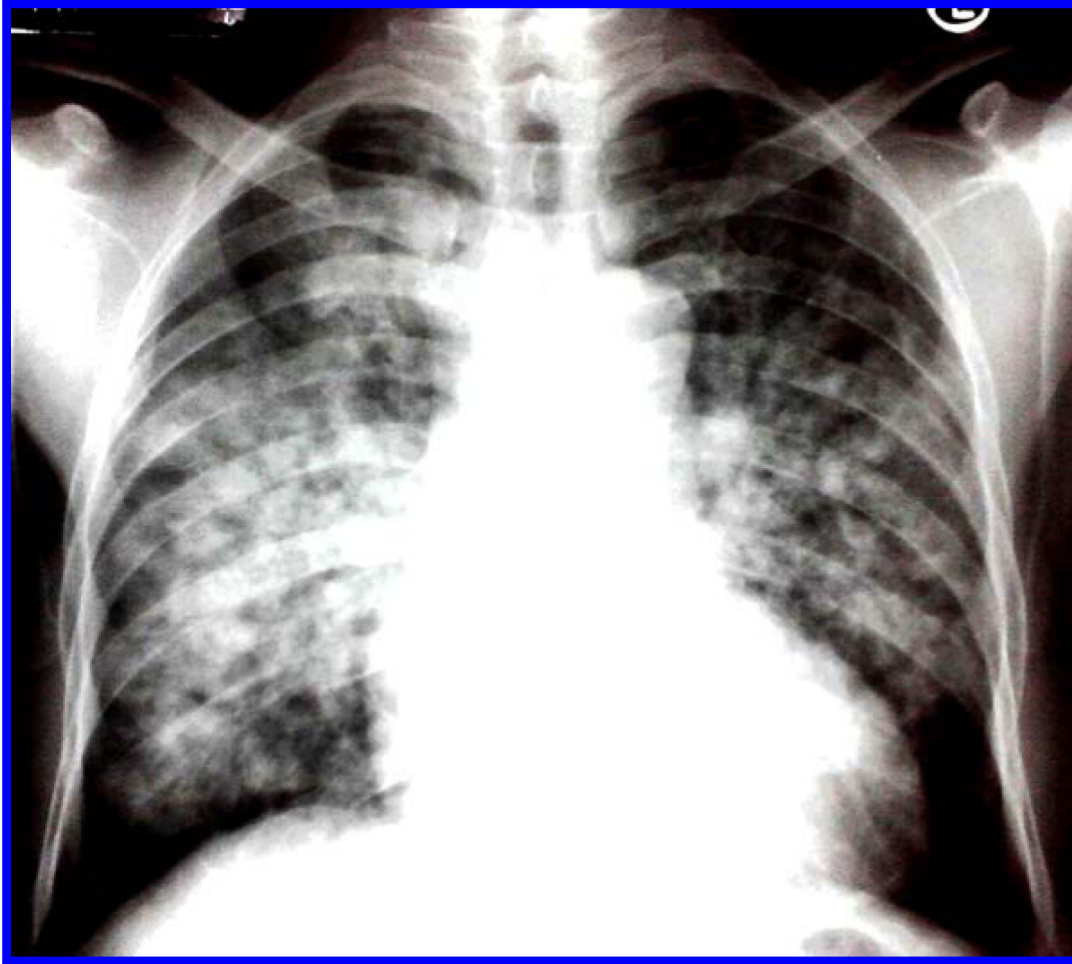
Chest radiograph showing bilateral alveolar pulmonary infiltration with ARDS in a patient with complicated *P. falciparum*
